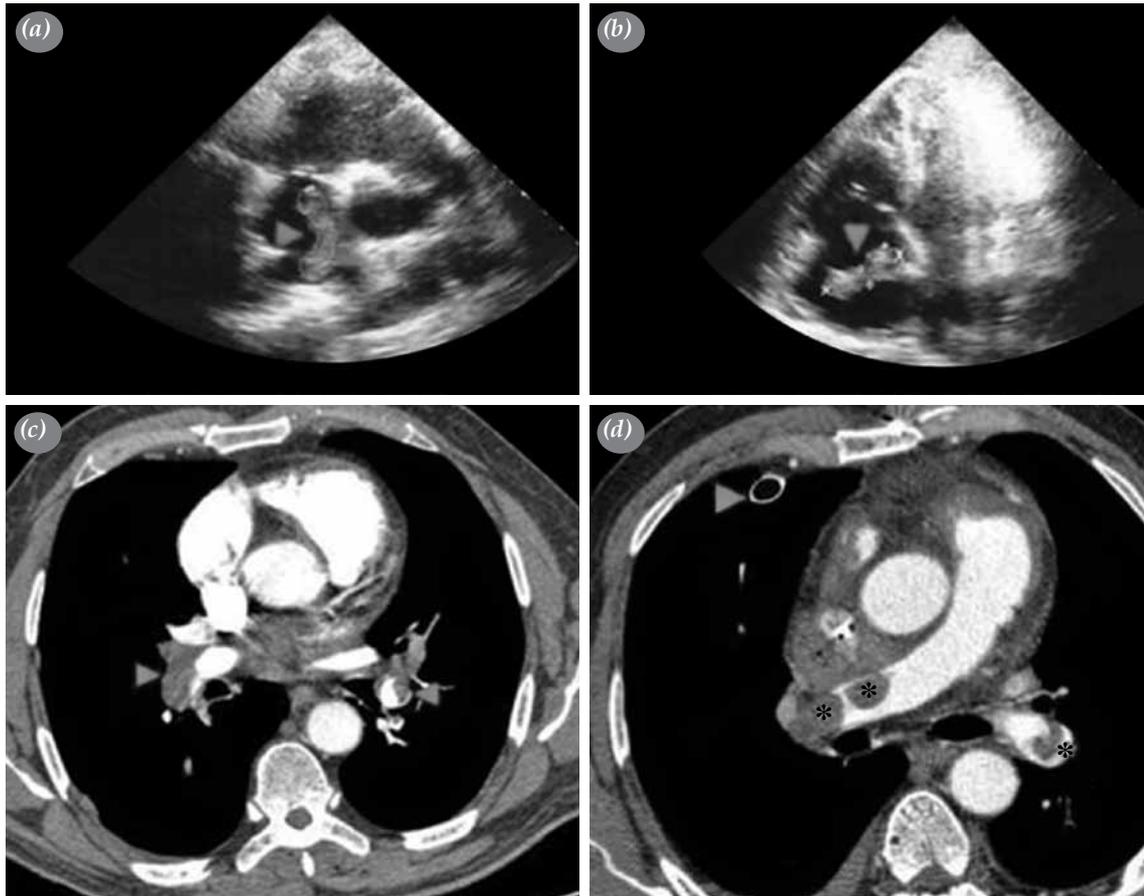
The echocardiogram (a, b) and transverse CT angiogram (c, d) of case 2 is shown. ▶ points to the mobile thrombus echogenicity in (a) and (b), and ▶ in (c) and * in (d) reveal the filling defects. ▶ in (d) indicates the left chest tube.
